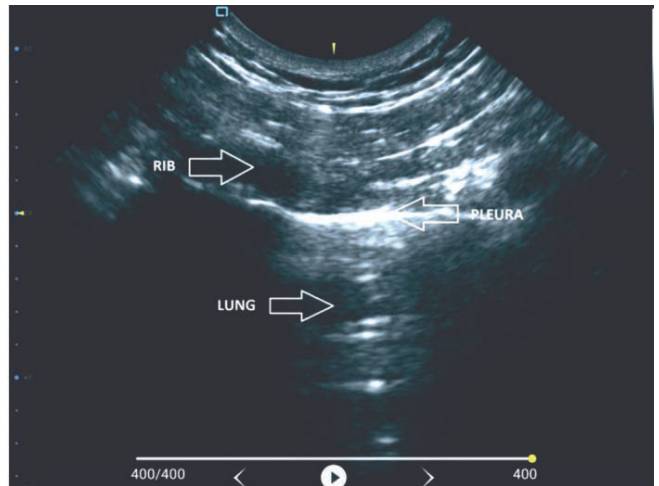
Ultrasound image during eFAST examination of the intercostal space
